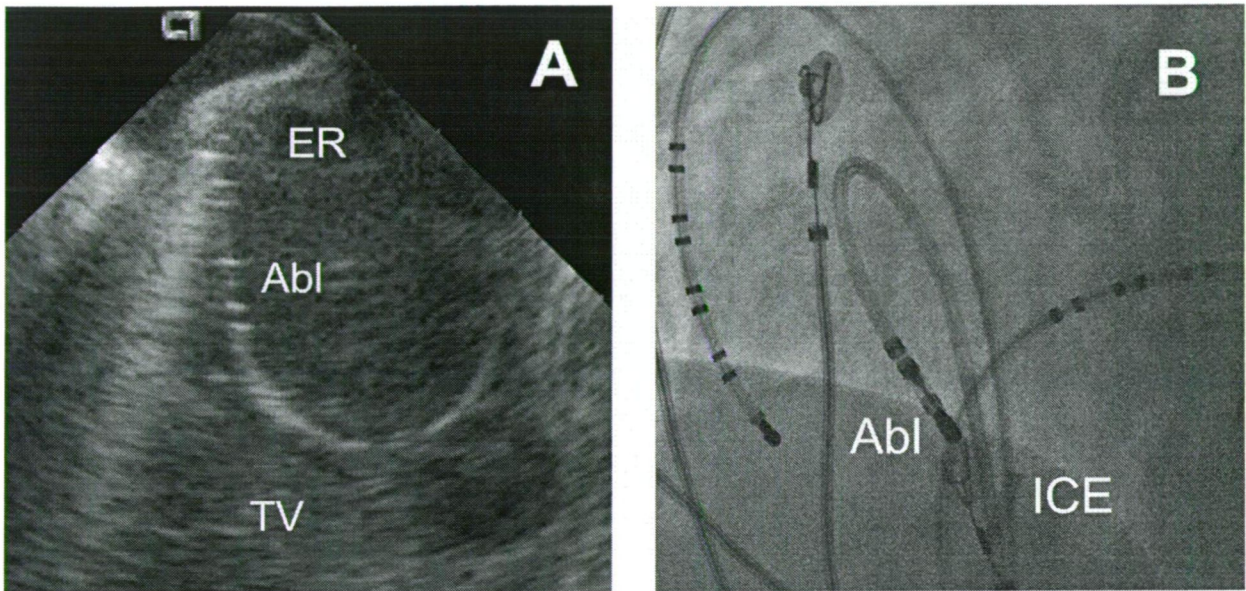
Intracardiac echocardiographic image (A) of the cavotricuspid isthmus. The ablation catheter (Abl) is curved around the prominent Eustachian ridge (ER). TV=tricuspid valve. Left anterior oblique fluoroscopy (B) showing the position of the ablation catheter (Abl). ICE=intracardiac echocardiography catheter.
